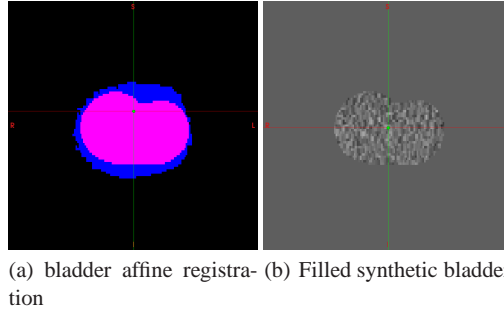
synthetic CT bladder reconstruction. (a) shows the overlap between synthetic (pink) and *subjectB* (blue) bladder after affine registration. The intensities of the *subjectB* bladder taken from the original CT are used to fill the synthetic one (b).
